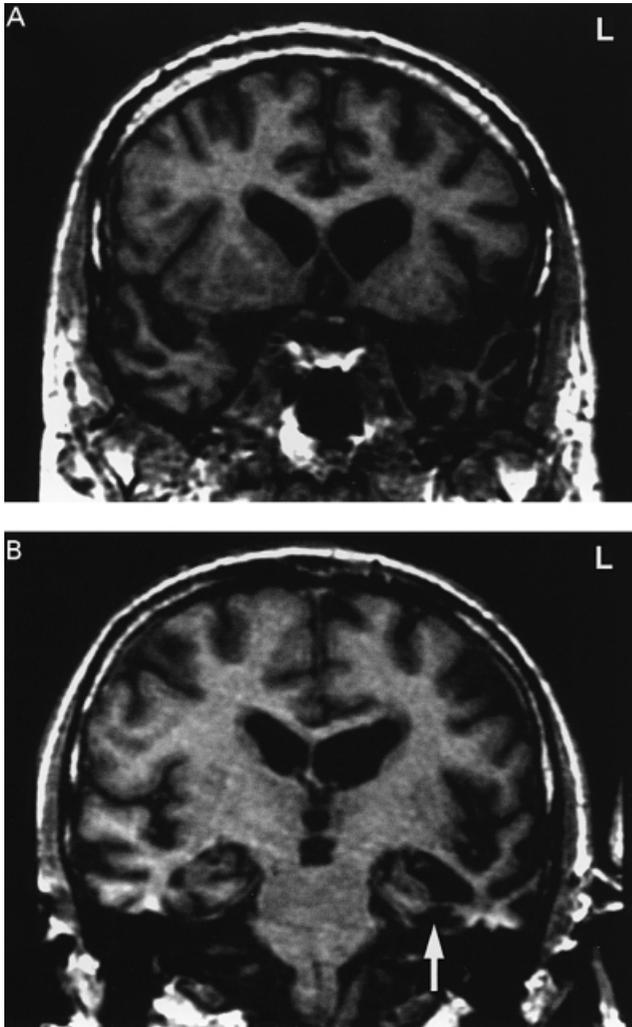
Two coronal MRIs, T₁-weighted, taken from A.M. in November 1995. (A) Severe left temporal pole atrophy with a lesser degree of shrinkage to the right temporal pole. (B) This scan reveals that the left-sided temporal lobe atrophy involves the infero-lateral region and, possibly, the superior temporal gyrus. Both hippocampi look relatively preserved, although there is evidence of some shrinkage to the entorhinal and perirhinal cortices on the left. Rating of A.M.'s brain from an MRI scan (February 1995) using measures developed by Galton *et al.* (2001) confirmed these observations, although there was also evidence of significant atrophy to the hippocampus and parahippocampal gyrus bilaterally [see Simons *et al.* (2000), Fig. 1].
